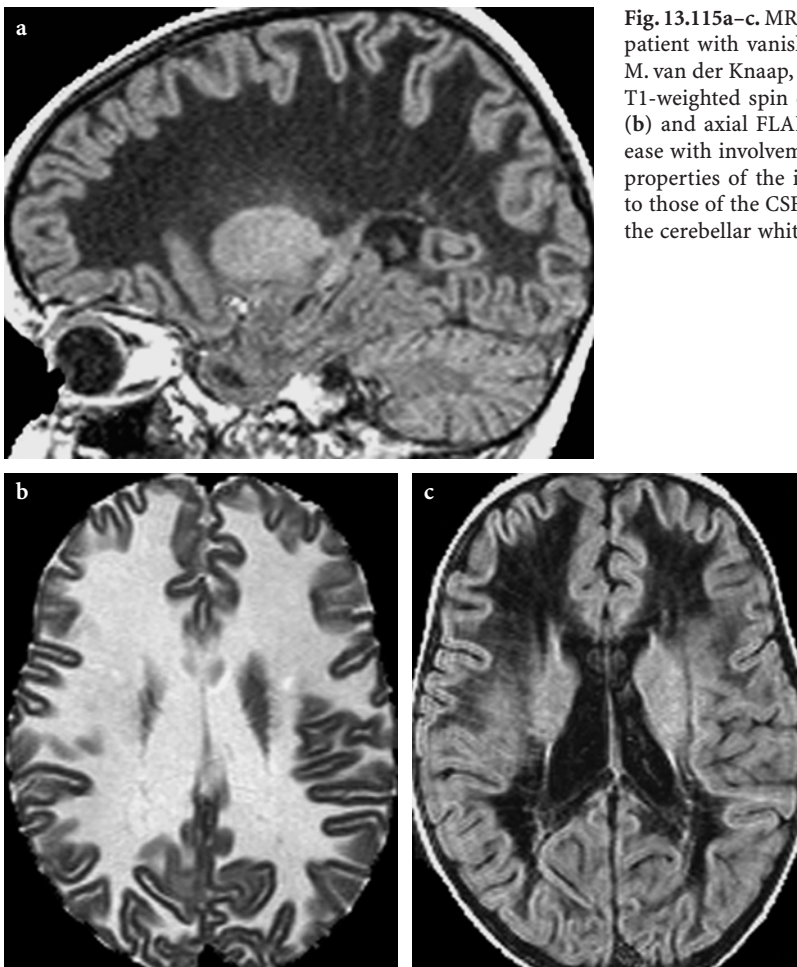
MR imaging findings in an 18-year-old female patient with vanishing white matter disease (courtesy of Dr. M. van der Knaap, Amsterdam, The Netherlands). a–c Sagittal T1-weighted spin echo (a), axial T2-weighted fast spin-echo (b) and axial FLAIR (c) images. Extensive white matter disease with involvement of the subcortical U-fibers. The signal properties of the involved white matter are almost identical to those of the CSF on all images. Note the relative sparing of the cerebellar white matter
